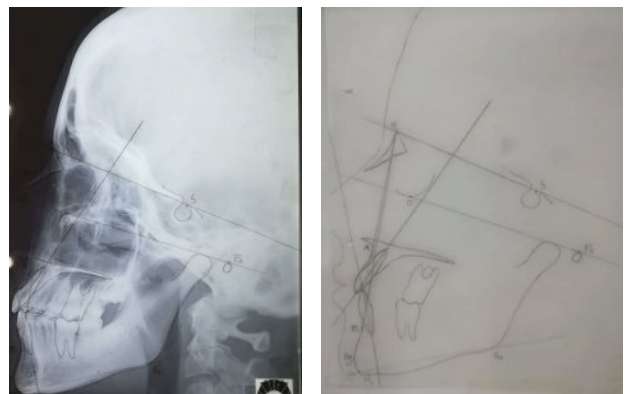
Final Cephalometric radiograph
